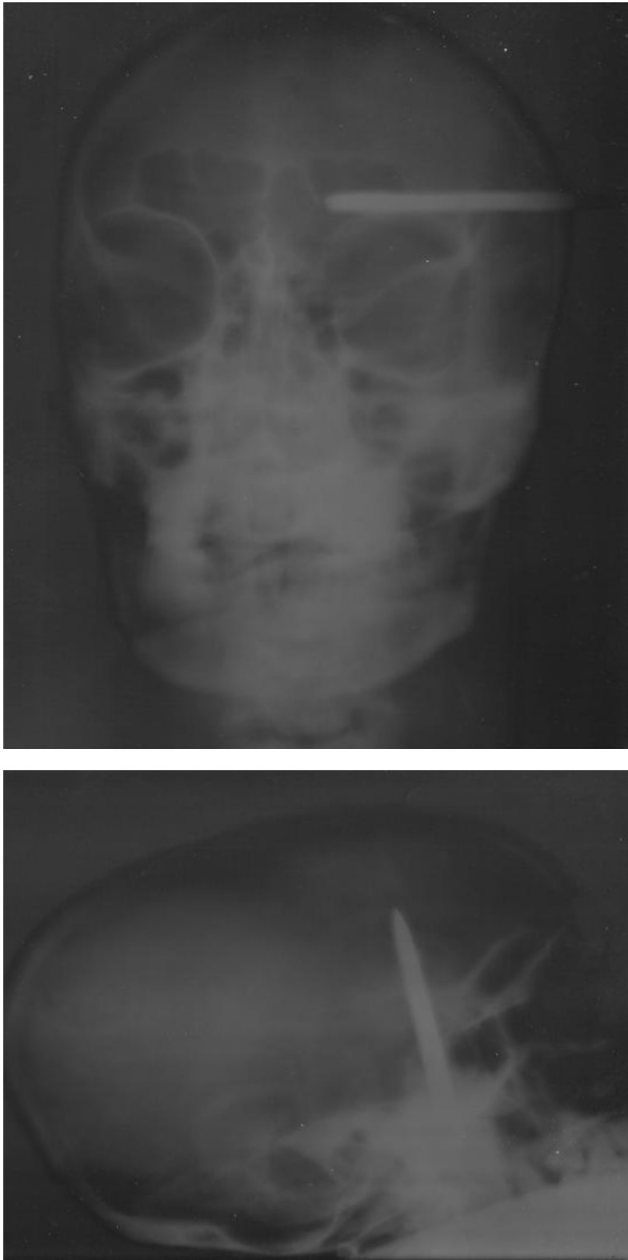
X-rays images of head with screw driver in cranial cavity.
